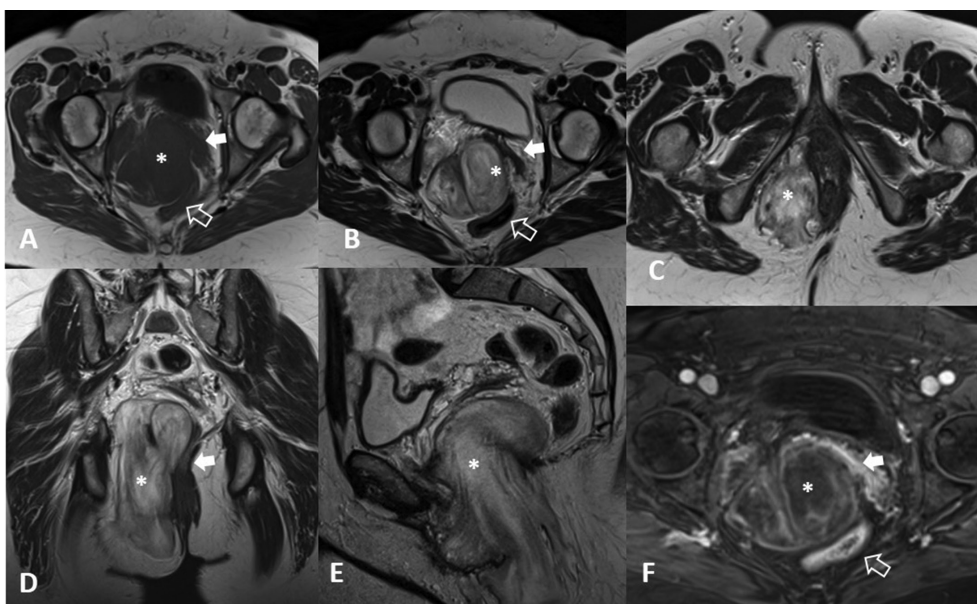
Axial T1-weighted (A), axial T2-weighted (B,C), coronal T2-weighted (D), sagittal T2-weighted (E) and axial T1-weighted fat-saturated gadolinium-enhanced (F) sequences showing a homogeneously hypointense lesion (white asterisk) on T1-weighted sequences (A), with heterogeneous high-signal intensity on T2-weighted sequences (B–E). The lesion enhances intensely (F). The laminated appearance given by the multiple hypointense strands is better depicted on the coronal (D) and sagittal (E) planes, which on the axial plane accounts for the whorled appearance (B). The 'hourglass' shape is seen on (E). No invasion of adjacent structures is present. White open arrow, rectum; white arrow, vagina.
